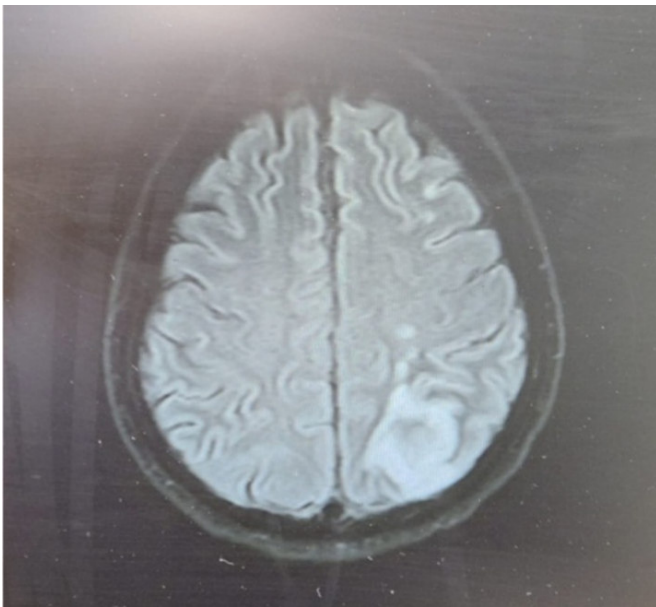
MRI brain showing infarcts in left middle cerebral artery/posterior cerebral artery territory
